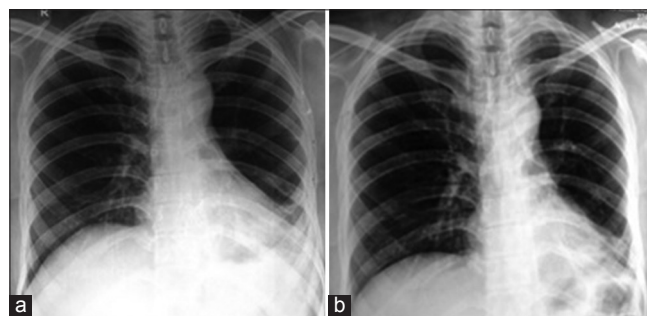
Chest X-ray after (a) 1 month and (b) 2 months of surgical drainage of fluid shows the left pleural thickening with no recurrence of effusion
